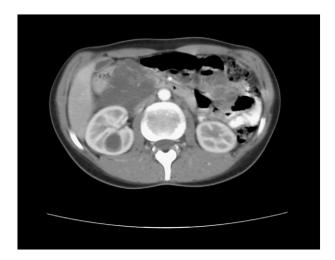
Contrast-enhanced CT scan of Case 1, which shows a hypodense cystic mass with irregular enhancing septations.
